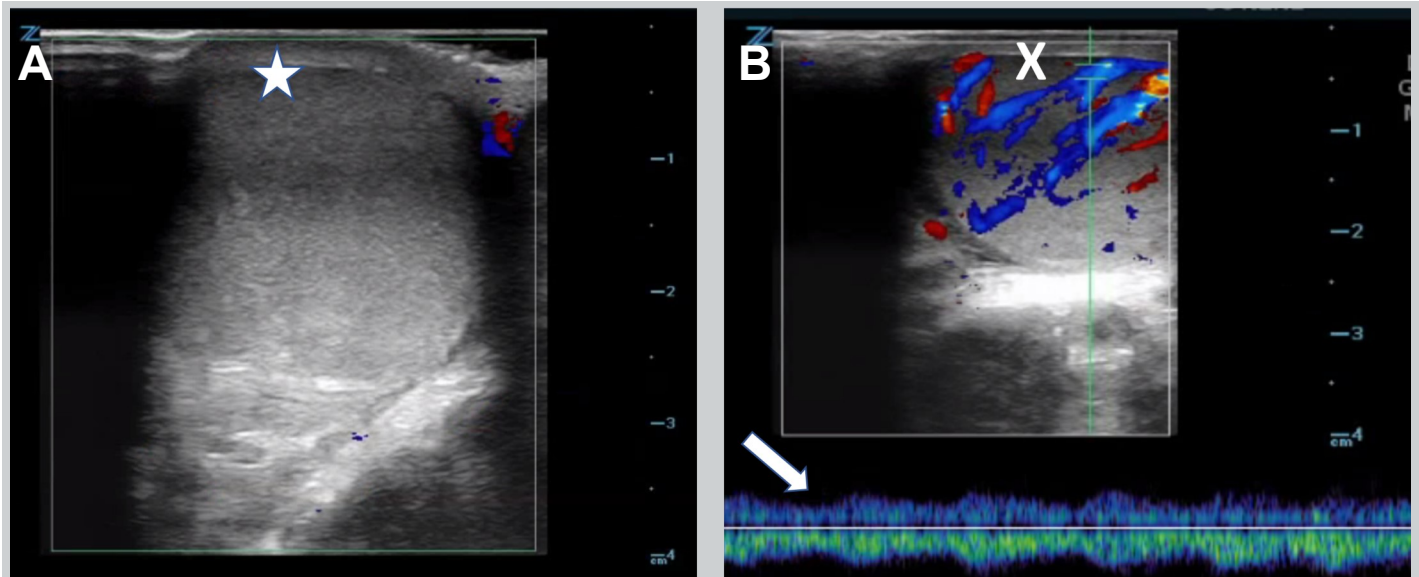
Doppler ultrasound imaging of right testicle during attempted detorsion. A) There was still absence of blood flow after initial detorsion attempt demonstrated by lack of color signal over the right testicle (star). B) After additional detorsion, color signal is now visible over the right testicle (X) and return of arterial waveform on pulse wave doppler (arrow), indicating restoration of blood flow.
